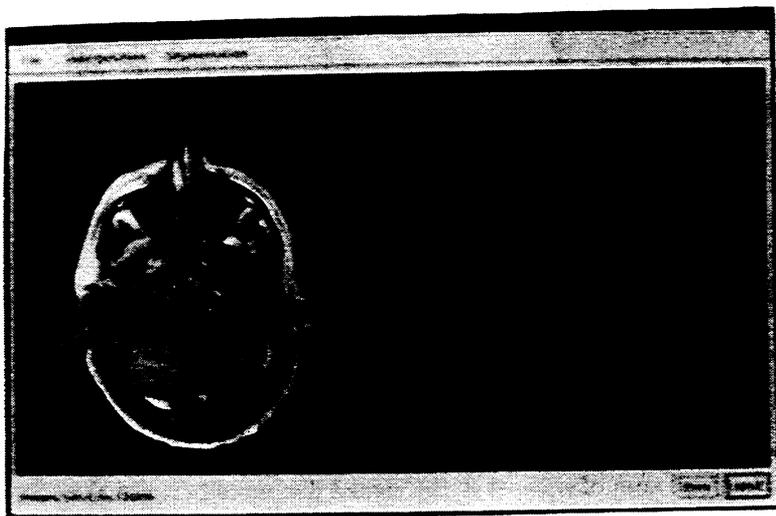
superimposition of MRI and resliced CT images after registration using the scalp surface. The result is visually perfect.
